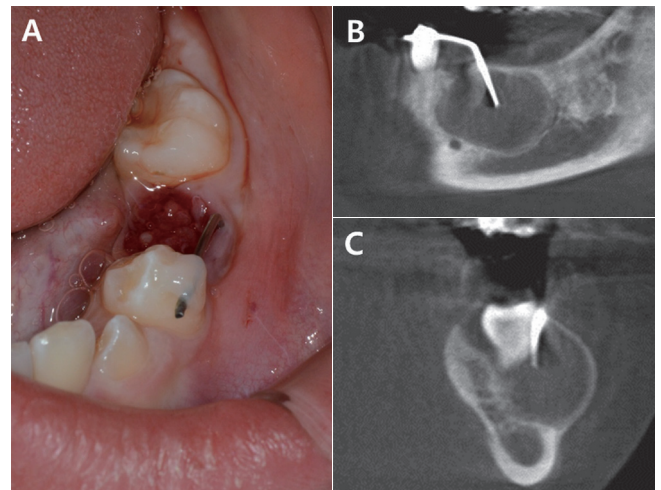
Intraoral photo (A) shows that the metal tube for decompression was inserted through the extraction socket after the involved primary tooth was removed. The opposite end of the tube was fixed to the adjacent tooth with flowable resin for stability. The appropriate position of the decompression tube can be seen on the sagittal CT view (B) and the coronal view (C).
